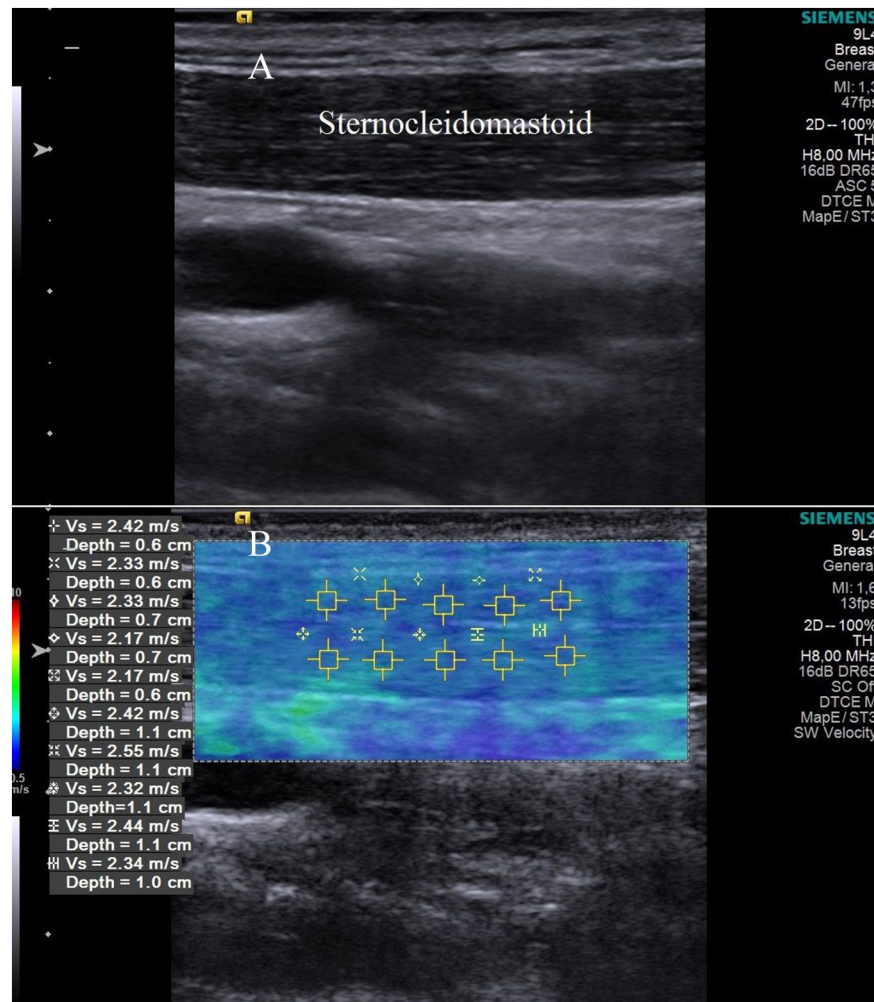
Two-dimensional ultrasound of the sternocleidomastoid muscle (A). Color map shear wave elastography image of the sternocleidomastoid muscle in the longitudinal plane (B). Ranges of image were placed in the muscle, and corresponding shear wave velocity (m/sec) values were recorded. The shear wave velocity of the tissues increases in the order of blue-green-red color-coded areas.
